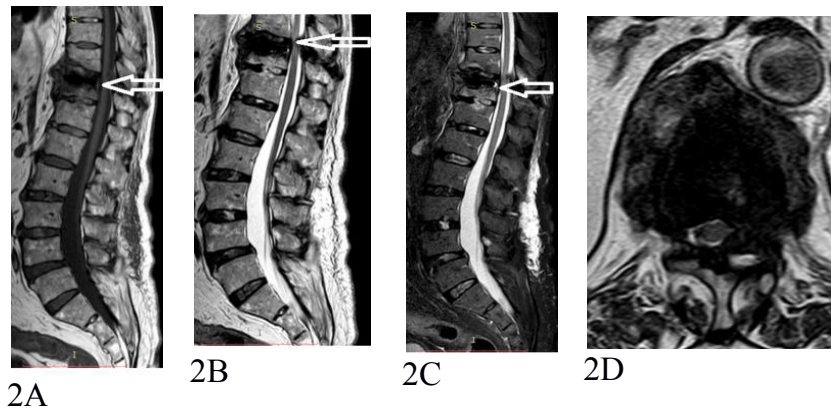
MRI carried out 9 months after the fall, the T11 body has collapsed and it shows a low signal area in the sagittal sequence T1 (2A) and T2 (2B), while the sequences STIR highlights a cancellous bone inflammation (2C); from the axial scan is more evident the fibrous reaction surrounding the necrotic area (2D).
